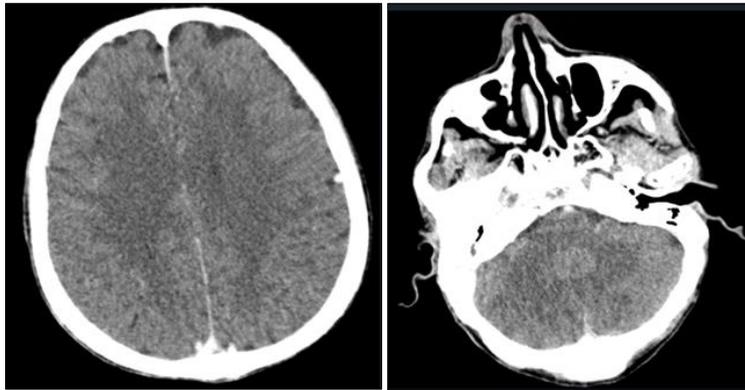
Axial brain CT scan with contrast injection showing no significant abnormalities
